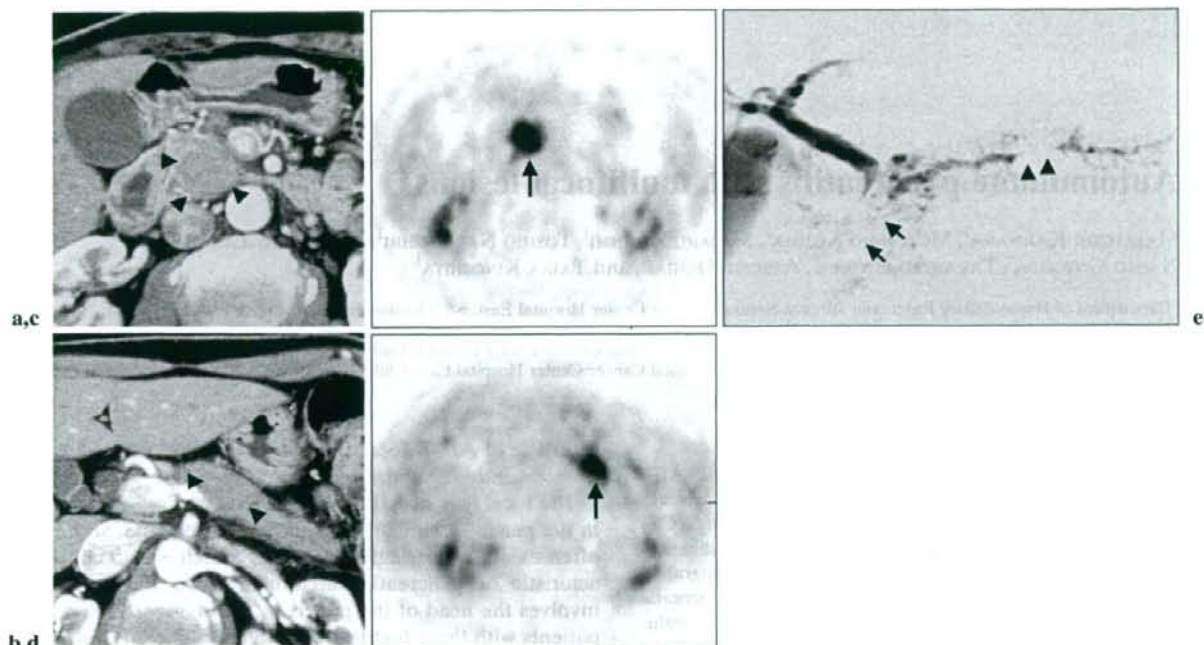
Case 1. Computed tomography (CT) revealed irregular mass lesions in the head (a) and body (b) of the pancreas (*arrowheads*); early phase. c, d Fluorodeoxyglucose positron emission tomography (FDG-PET) showed intense uptake in both lesions (*arrows*), and their standardized uptake
